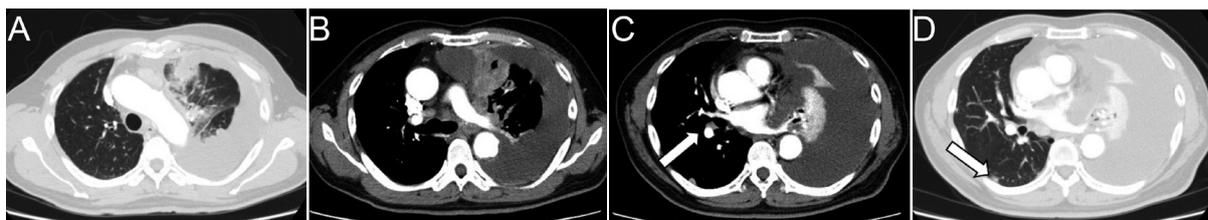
Chest CT scan on admission. Primary tumor in the left upper lobe showed direct invasion into the mediastinum with left pleural effusion and pleural nodules (A and B). Contralateral hilar lymph node metastasis (C, arrow) and contralateral pulmonary metastasis (D, arrow) were also suspected.
